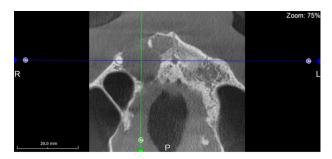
CBCT axial view shows resorbed labial & palatal cortical bone.
